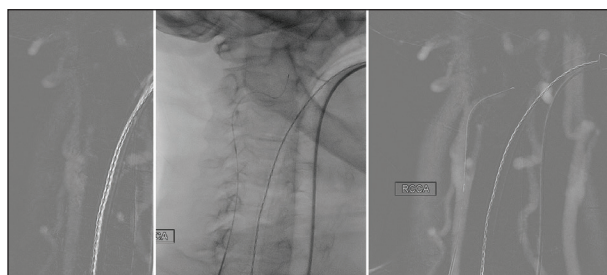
Ultrasound and roadmap-guided direct carotid puncture.
